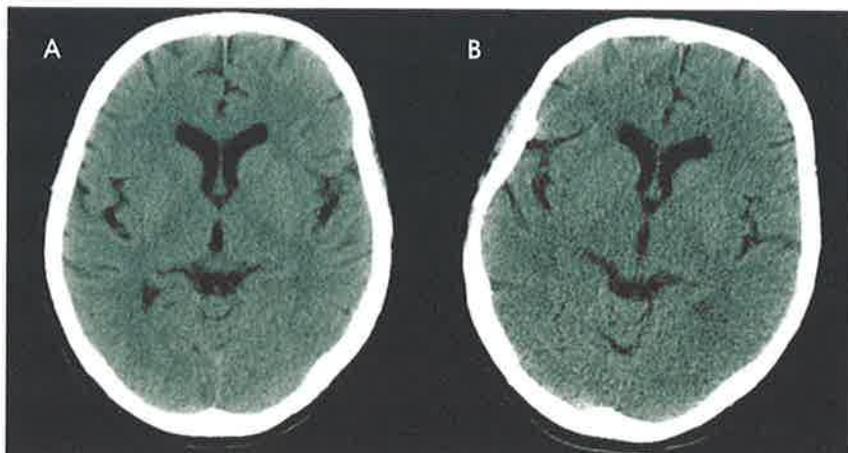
The image noise increases when the tube current decreases. (A) The initial adult CT examination was obtained with kVp 140, mA 280, slice thickness 5 mm, rotation time 1 sec. (B) Thirteen days later, the patient returned for a repeat scan on the same CT scanner. This scan was acquired using a tube current of 140 mA (all other scan parameters constant). Note the increased noise in this image. (Window 80, level 40 in both images.)
